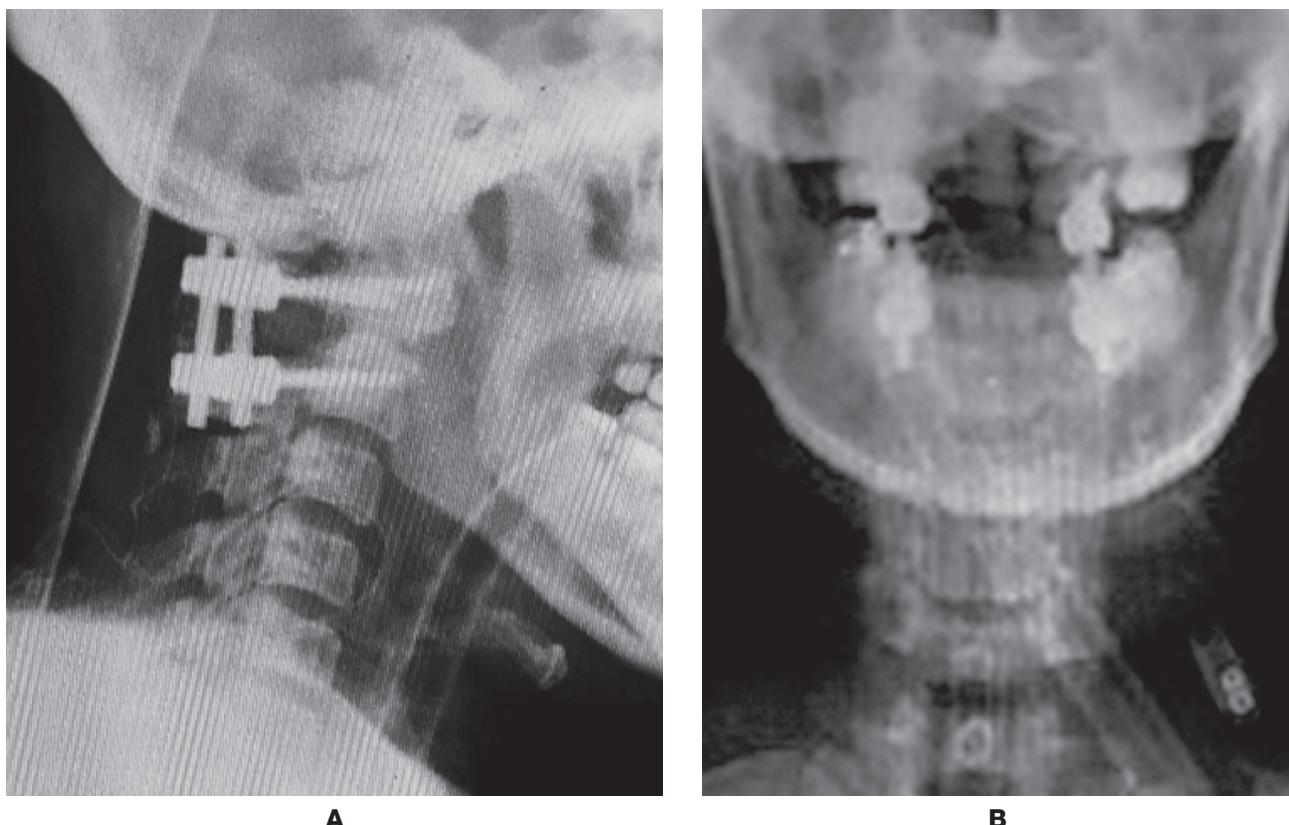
Postoperative radiographs in lateral view (A), and anteroposterior view (B)
